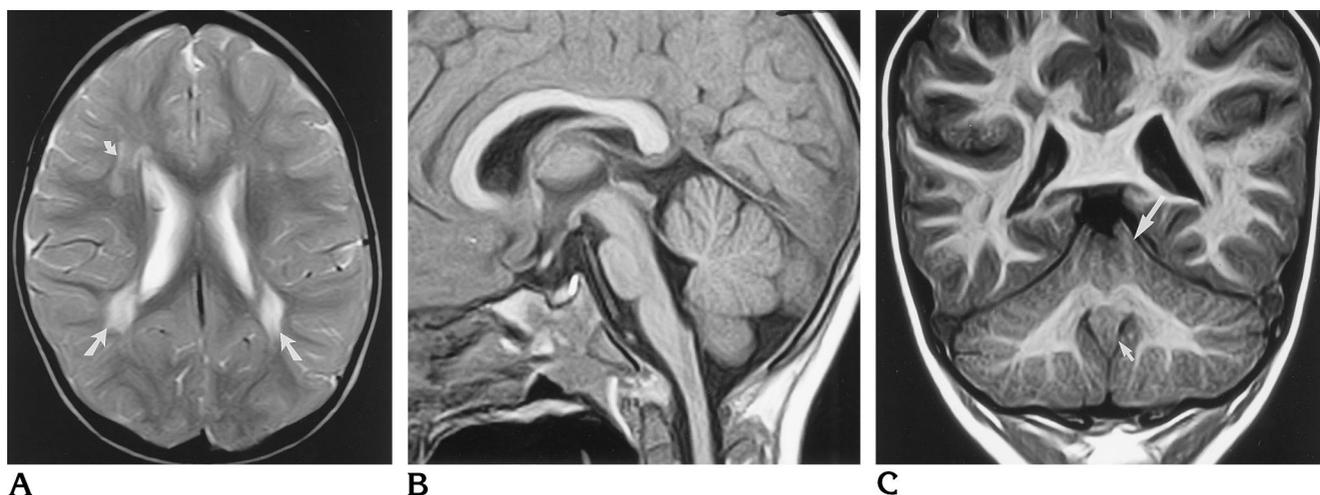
Case 10: 2-year-old boy with partial congenital ocular motor apraxia, abnormal white matter, but a normal cerebellum. A, Axial fast spin-echo T2-weighted MR image (3555/80/2) shows symmetric hyperintensity in the periventricular white matter (arrows). The child was not premature and there was no white matter volume loss on T1-weighted sequences. A presumptive diagnosis of leukodystrophy was made, but no biochemical abnormality was identified.
